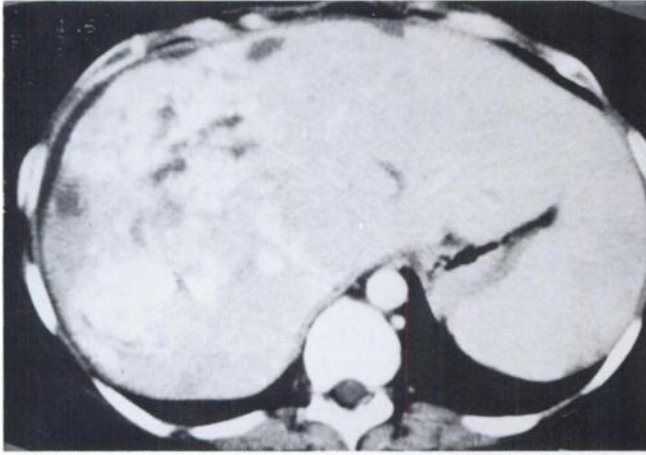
Iodized oil (Lipiodol)-enhanced CT of the liver following chemoembolization demonstrating multiple foci in the right liver lobe, indicating progression of the disease.
